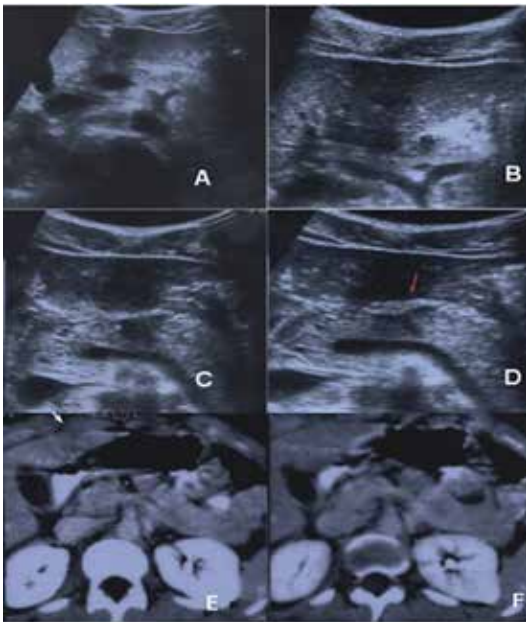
Pancreatic trauma. Images “A”, “B”, “C”, “D” are from ultrasound and “E” and “F” are from computed tomography with contrast<sup>10</sup>.
